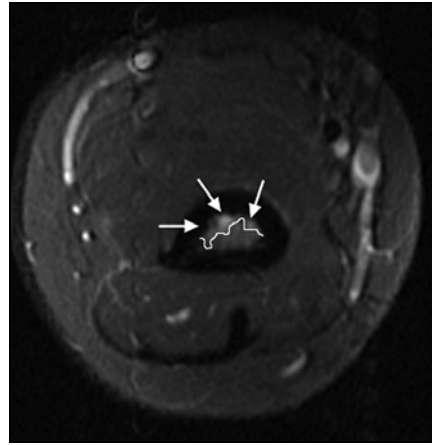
23-year-old male professional tennis player with distal humeral stress reaction. Axial STIR MR image shows patchy increased signal intensity (*arrows*) within anterior aspect of marrow cavity occupying 38% (*outlined*) of total cross-sectional area.
